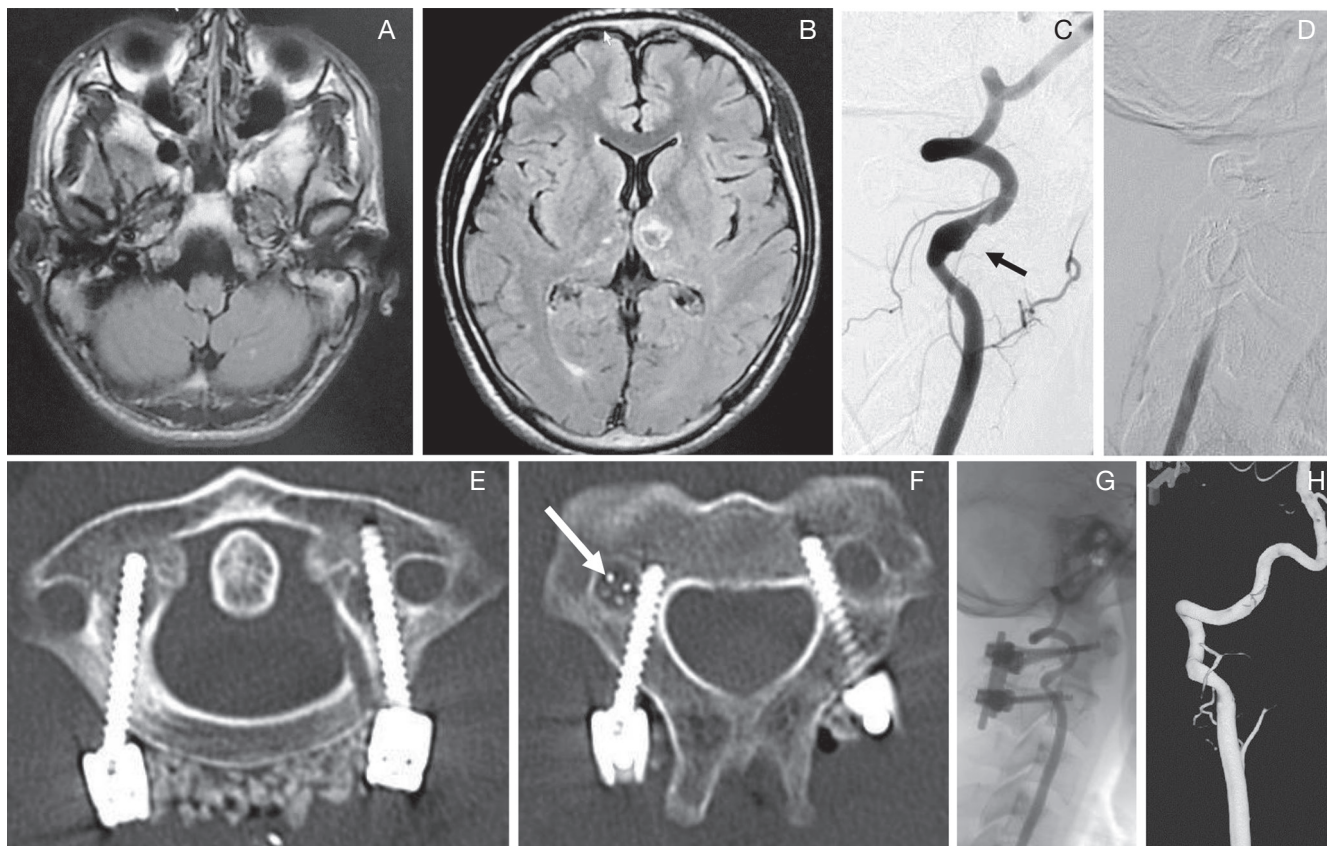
Neuroimaging in case 2. A, B: Magnetic resonance imaging showing multiple high intensity spots in the cerebellum and thalamus on a fluid-attenuated inversion recovery image. C: Vertebral angiography demonstrating stenosis and dilatation of the right vertebral artery (VA) just distal to the C2 transverse foramen after stenting (*arrow*). D: Angiography shows right VA occlusion during leftward rotation of the neck. E, F: Postoperative cervical X-ray film showing screws inserted for C1–2 posterior fixation and a stent in the right VA at the C2 level (*arrow*). G, H: Postoperative angiography showing resolution of VA dissection.
